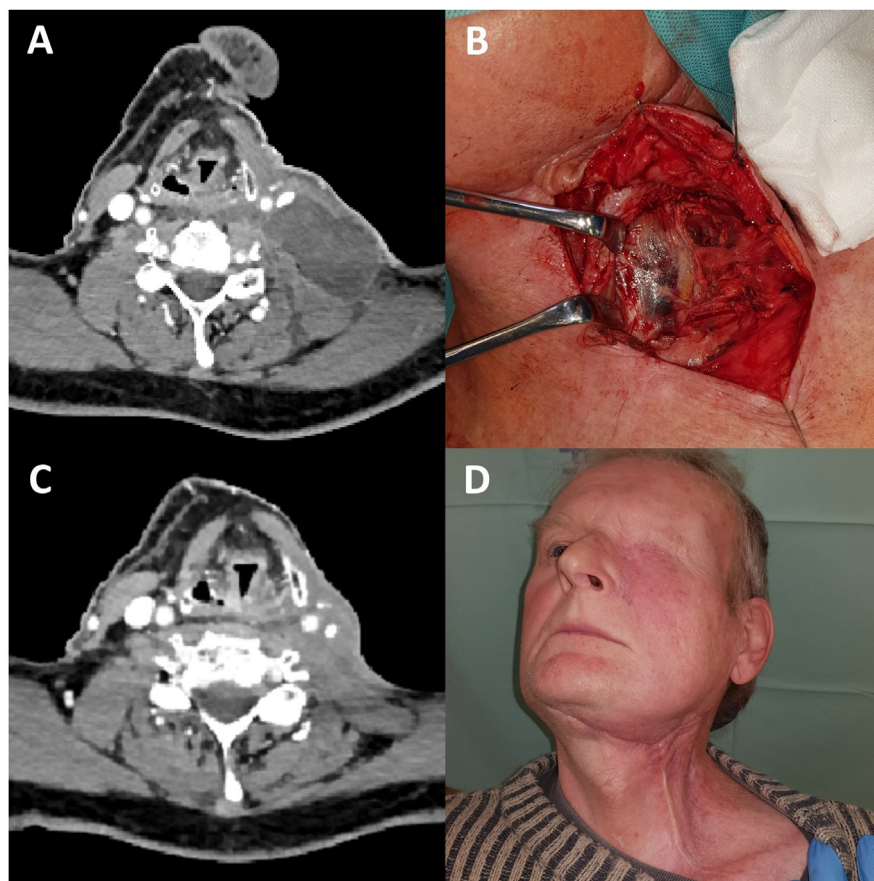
(A) Axial CT scan showing the lymphocele in the left V neck level (Image courtesy of Department of Imaging Methods, University Hospital and Faculty of Medicine in Pilsen, Charles University) and (B) the intraoperative view of this lesion. (C) The axial CT scan (Image courtesy of Department of Imaging Methods, University Hospital and Faculty of Medicine in Pilsen, Charles University) and (D) clinical state after the lymphocele resolution.
